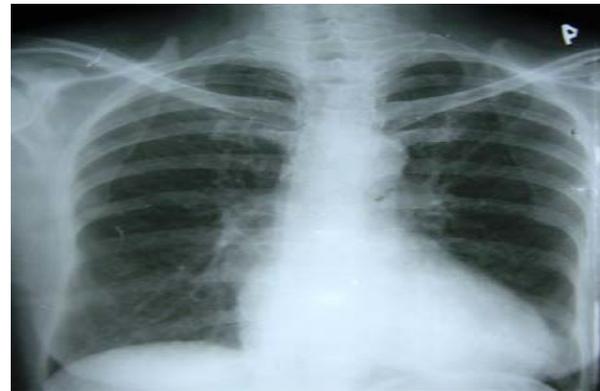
Fig a,b,c :Serial chest radiographs of patients of patients at time of admission and serial follow-ups.
